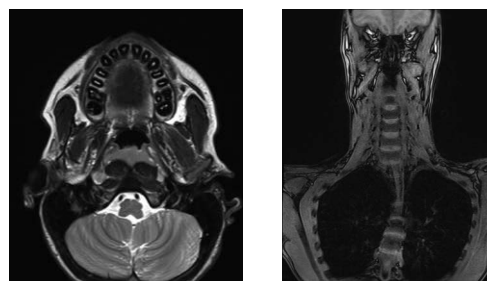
MRI scans in 1-year follow-up
